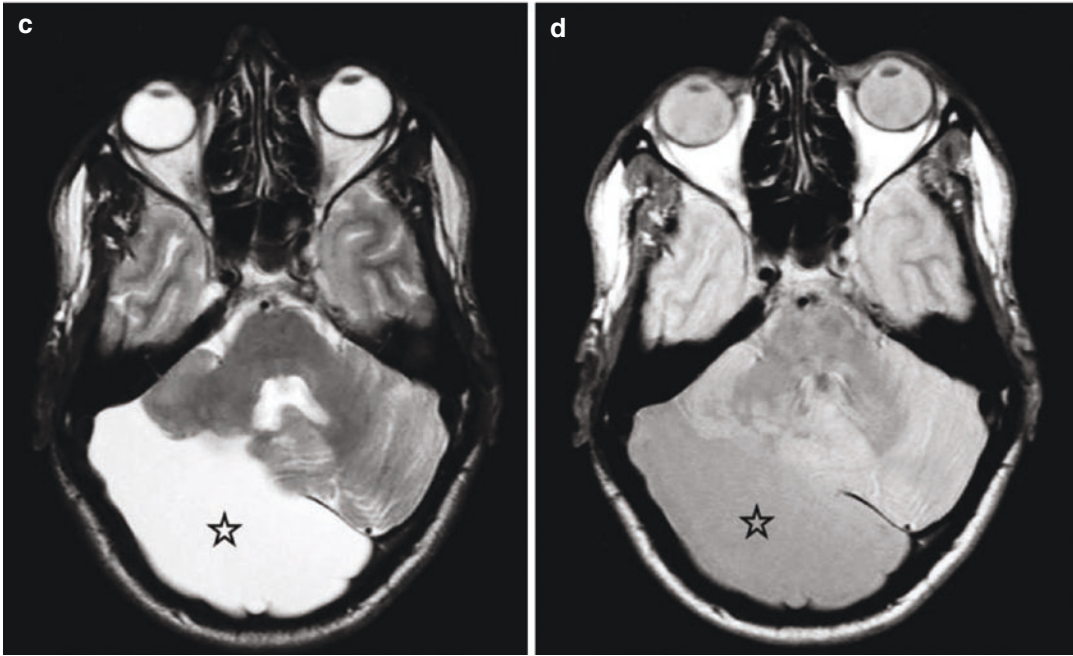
Same case as Fig. 4. Cerebellar AC on MRI (stars). Sagittal T1-weighted MRI (a) and coronal T2-weighted image (b)
